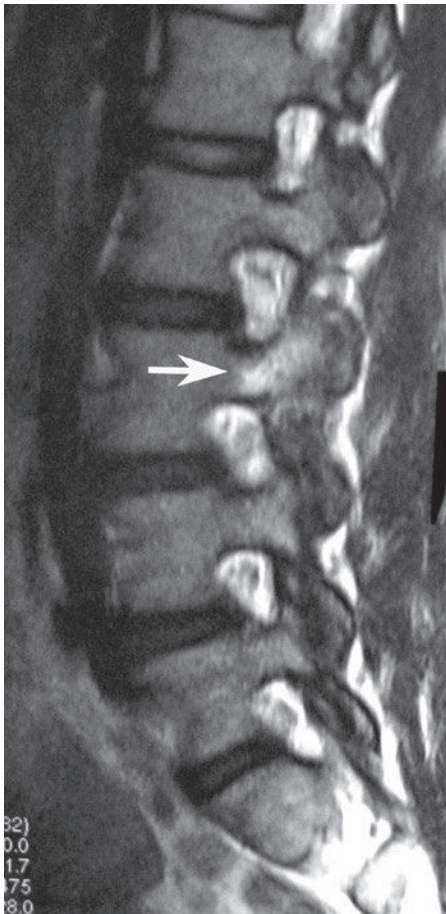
In this 12-year-old boy with persistent low back pain and normal radiographs, a parasagittal T2-weighted image shows an area of increased signal (*arrow*) within the region of the pars intraarticularis, compatible with edema from an acute or subacute nondisplaced pars intraarticularis fracture.
